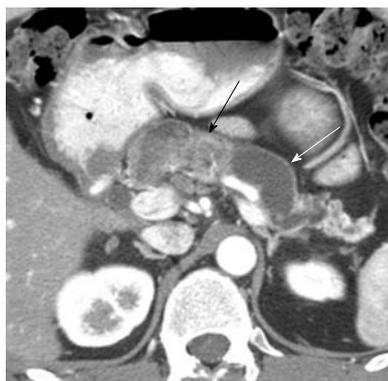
A 48-year-old man presenting with pancreatitis and exocrine pancreatic insufficiency and a mass in the pancreas representing diffuse intraductal papillary mucinous neoplasm of the pancreas. Axial contrast-enhanced computed tomography of the abdomen shows dilated main pancreatic duct (white arrow) due to mucin production and an enhancing mass in the main pancreatic duct (black arrow) representing a main duct intraductal papillary mucinous neoplasm.
